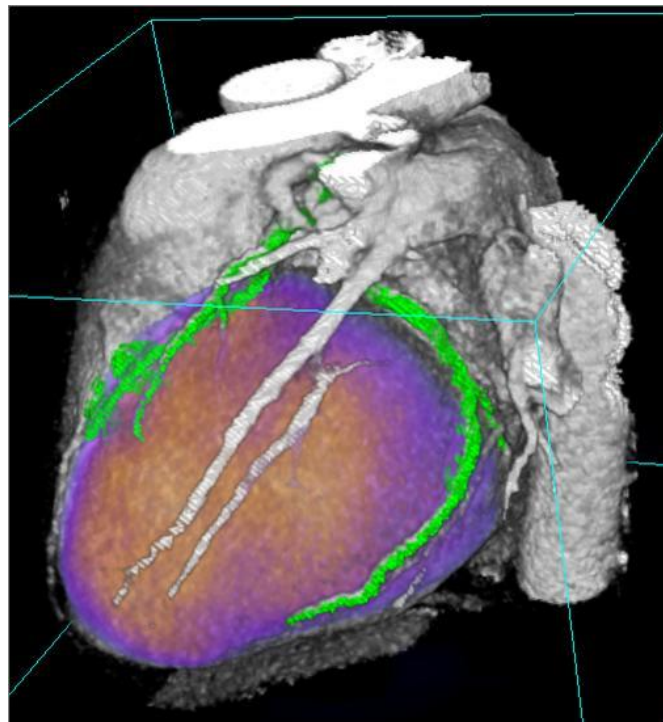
Color-coded fusion of a CTA with an $^{13}\text{N-NH}_3$ -PET perfusion study. Combined PET/CTA can allow identification of the stenosis and the assessment of their functional impact.
